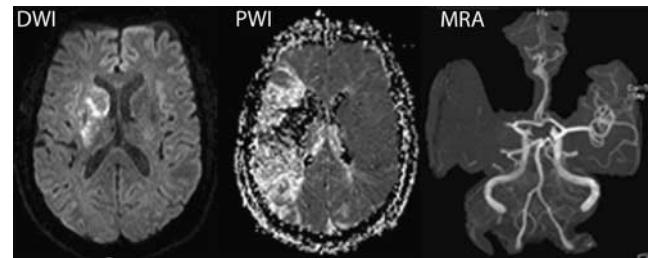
Identification of the diffusion/perfusion weighted imaging (DWI/PWI) mismatch. Diffusion-weighted images (left) and perfusion-weighted images (middle) in an 80-year-old patient at 8 h after the onset of acute aphasia, left-sided sensorimotor hemiparesis, and hemianopsia. *Note:* the small hyperintense lesion in DWI compared with the large area of hypoperfusion in PWI. Magnetic resonance angiography (MRA) reveals proximal occlusion of the left middle cerebral artery (kindly provided by J. Fiebach, Department of Neurology, Charité Universitätsmedizin Berlin).
